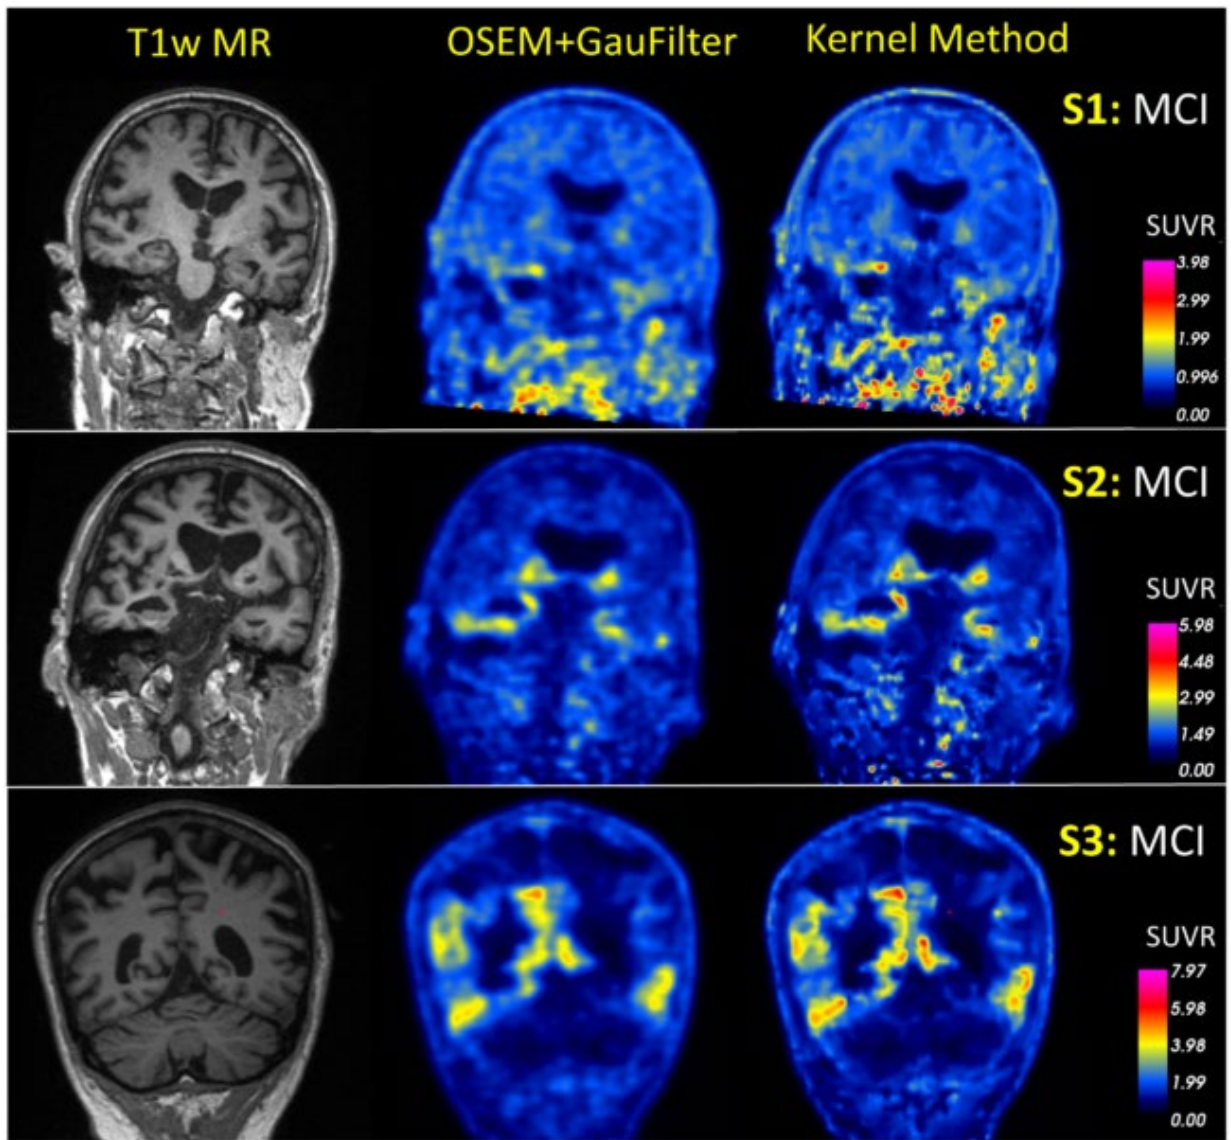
Coronal views of the SUVR images using the traditional Gaussian smoothing (4mm FWHM) and the proposed kernel method. The first column is the T1w MR image.
